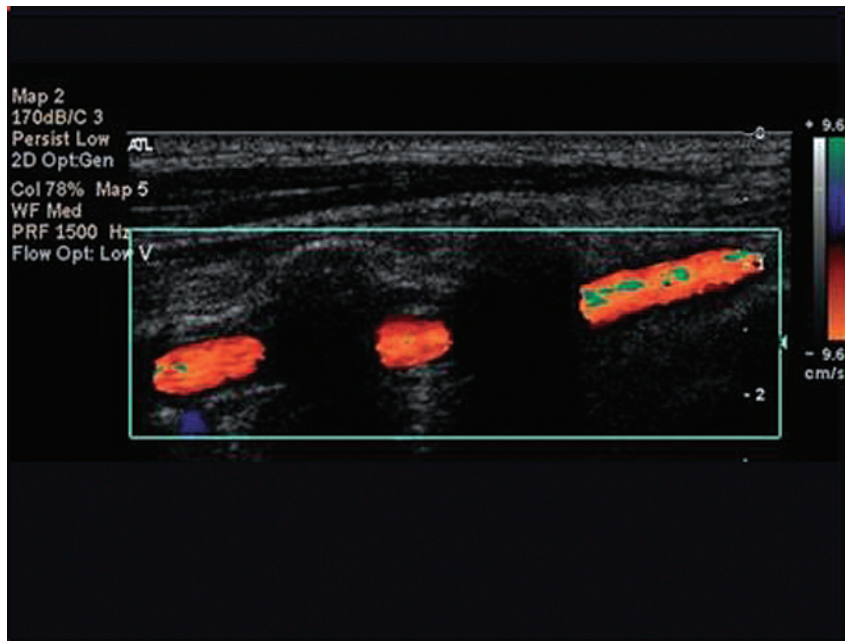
Color-flow image of a vertebral artery. Ultrasound cannot penetrate bone therefore there is no Doppler shift and no color where the artery passes through the vertebral foramen.
